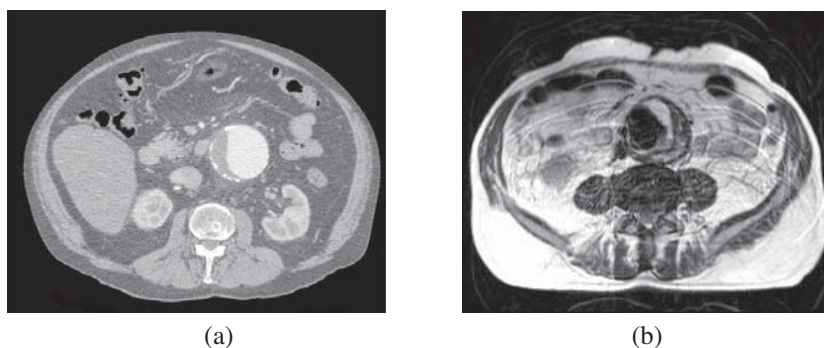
Examples of clinical imaging techniques to visualize AAA. a) show the CT image slice from the abdomen of an AAA patient, the aneurysm is seen to the right of the center in the image. b) show the MR image slice from the abdomen of another AAA patient, the aneurysm is seen in the center of the image with visualisation of the structure of the intraluminal thrombus in contrast to the CT image in a).
